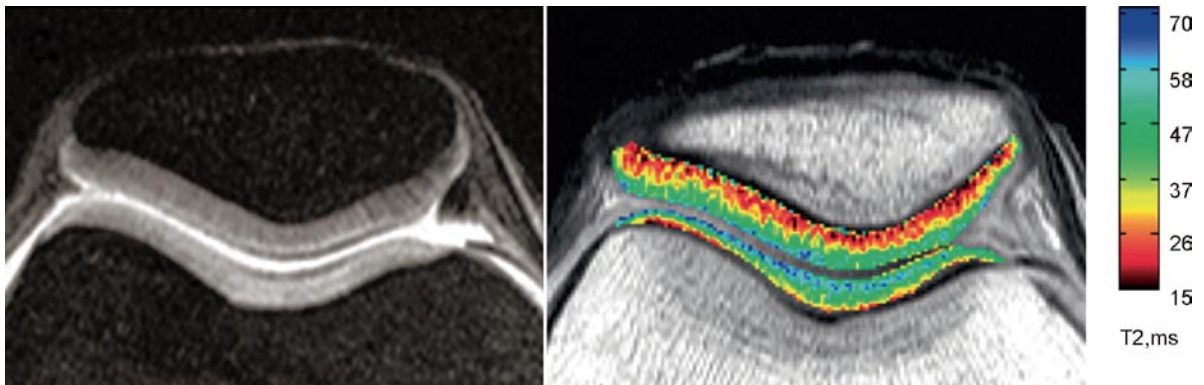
Axial MRI of Patellofemoral Joint Cartilage. (a) Example morphologic 3 T DESS image. Striations indicative of collagen fibril arrangement in the thick patellar cartilage are
